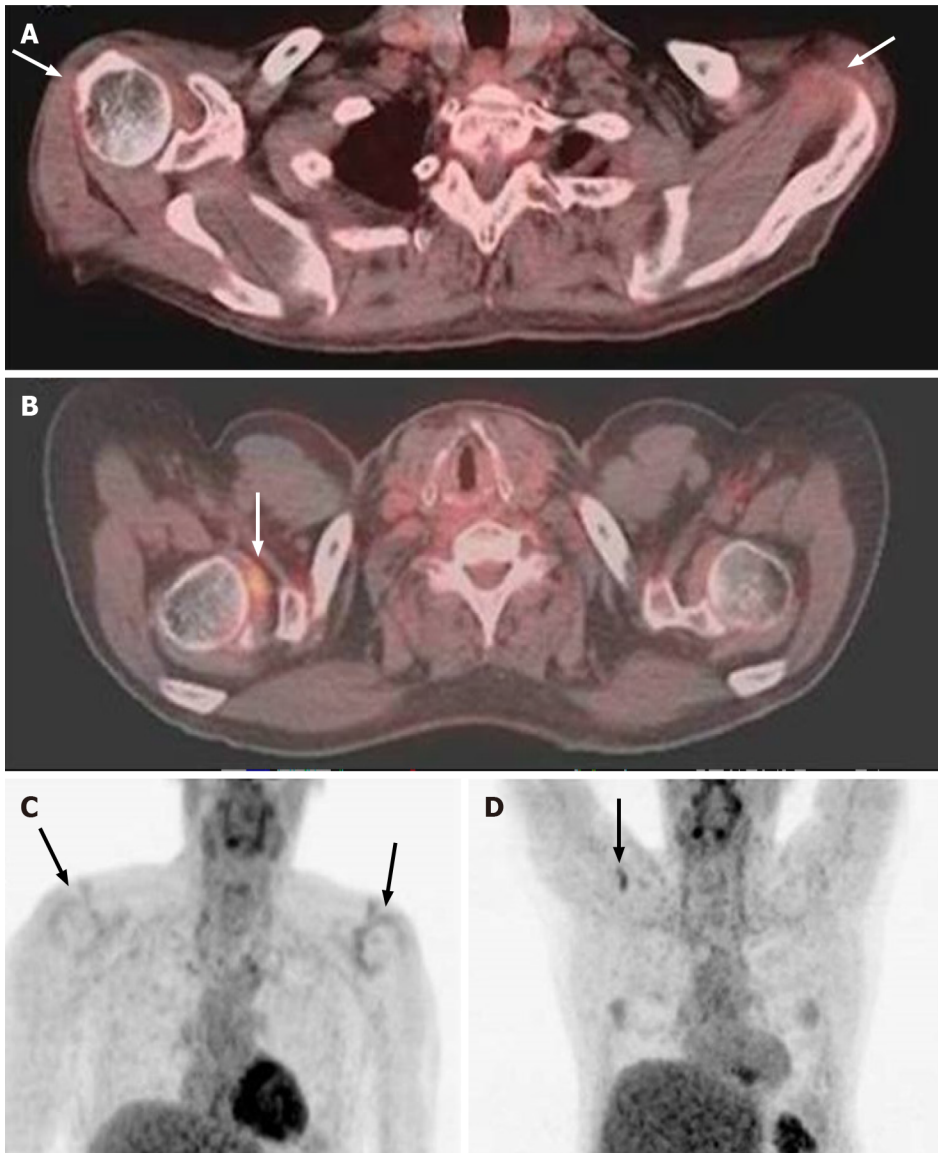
Fifty-six years old patient with lung cancer. Fused Positron emission tomography (PET) - computed tomography (A) and (C) maximum intensity projection (MIP) PET images demonstrate mild diffuse non-specific bilateral shoulder capsular FDG uptake at initial pre-therapy imaging (arrows, better seen on MIP images); B and D: After diagnosis of lung cancer and treatment, the patient developed right shoulder pain and more focal capsular uptake in the right shoulder capsule in the region of rotator interval (arrows).
